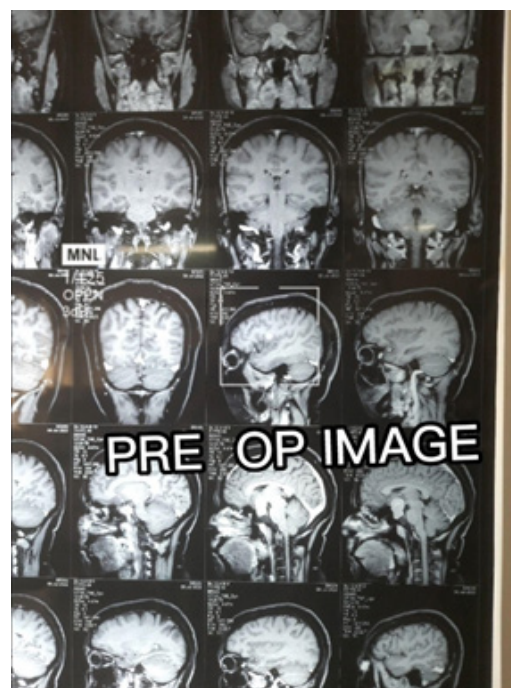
Pre operative MRI Brain
